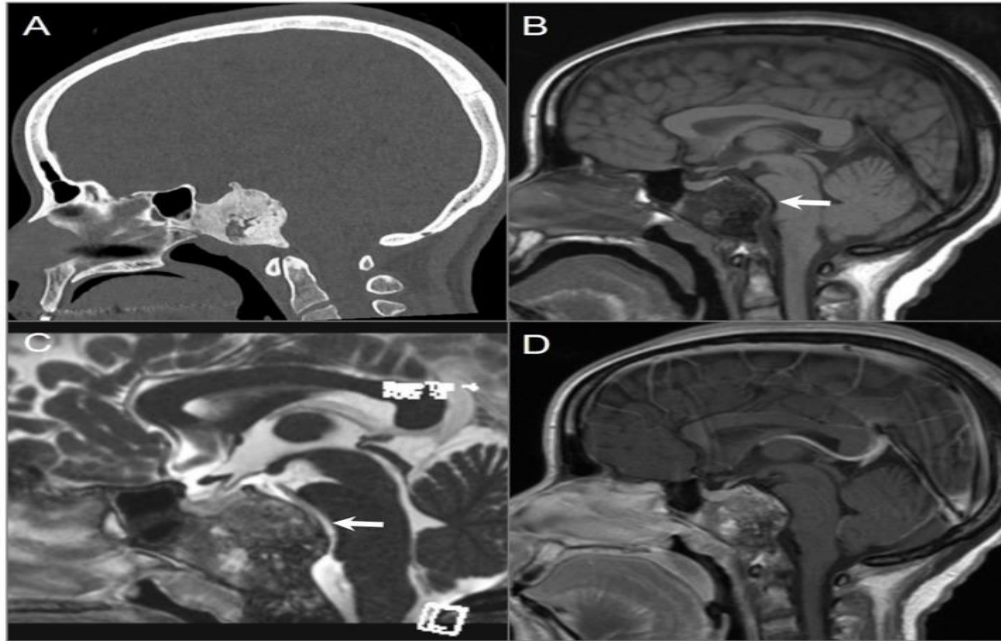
Fibrous dysplasia. (A) Sagittal CT image shows a well-defined expansile ground-glass density lesion in the clivus and posterior sphenoid sinuses. The lesion demonstrates peripheral sclerotic and central small lytic regions. (B,C) Sagittal T1W and postcontrast CISS images reveal T1 hypointense and variable T2 signal intensity in the lesion with mass effect on the brainstem and basilar artery (arrows). (D) Sagittal postcontrast T1-weighted image shows heterogeneous enhancement of the lesion.
